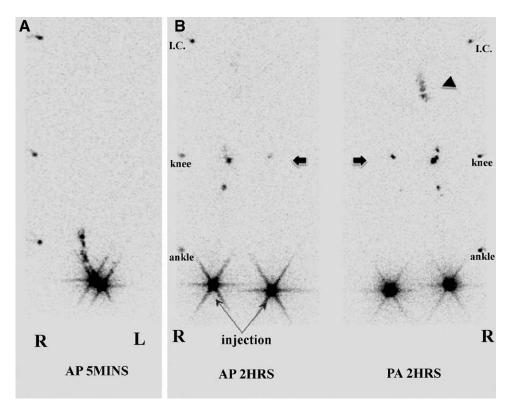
Lymphoscintigraphy revealed lymphatic tract on right foot but not on left foot at 5 minutes after Technetium-99 injection (A). Note that inguinal nodes appeared on right side but not on left side (arrow head) after 2 hours on the posterior-anterior (PA) view (B). Deep lymphatic trunks and several popliteal nodes were visible on both sides (black arrow) after 2 hours injection (B).
